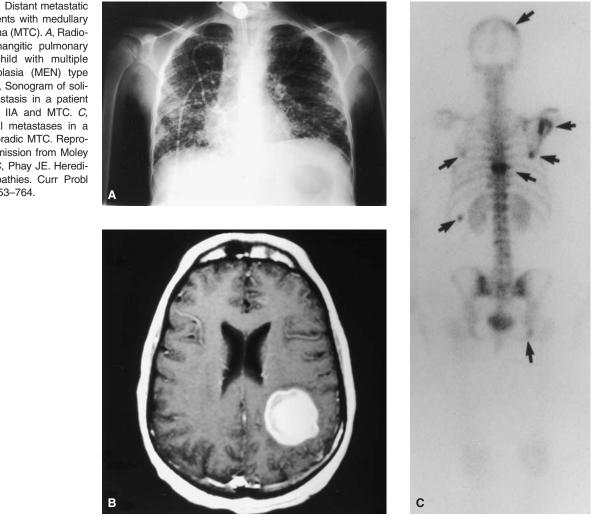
Distant metastatic disease in patients with medullary thyroid carcinoma (MTC). A, Radiograph of lymphangitic pulmonary spread in a child with multiple endocrine neoplasia (MEN) type IIB and MTC. B, Sonogram of solitary brain metastasis in a patient with MEN type IIA and MTC. C, Multiple skeletal metastases in a patient with sporadic MTC. Reproduced with permission from Moley JF, Lairmore TC, Phay JE. Hereditary endocrinopathies. Curr Probl Surg 1999;36:653-764.
